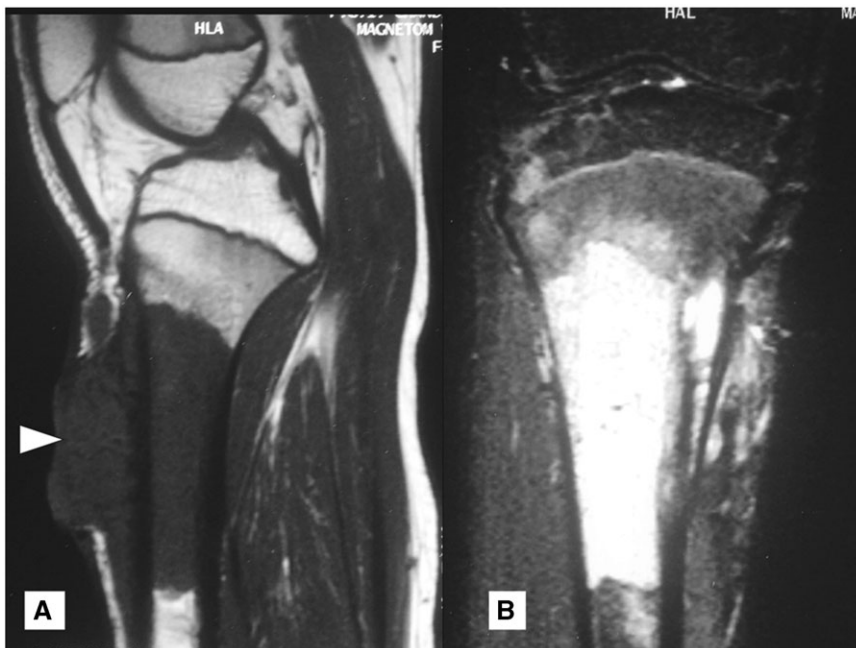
MRI sagittal T1-weighted (A) and fat suppressed coronal T2-weighted images (B) demonstrating abnormal marrow signal of the proximal metadiaphysis of the right tibia with sharp zone of transition. Also note the large soft tissue seen anteriorly (arrowhead, A).
